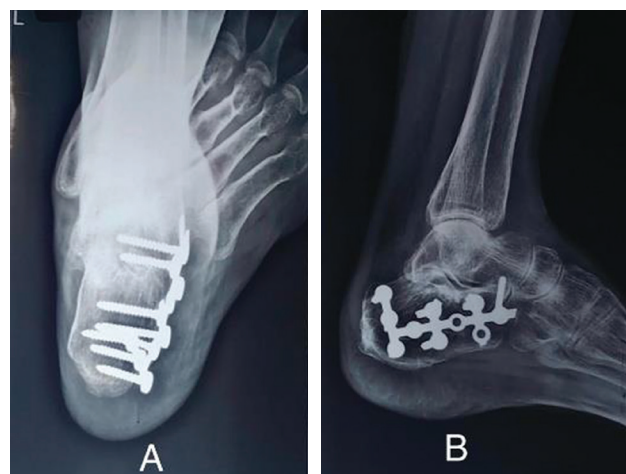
Immediate postoperative X-rays following calcaneal fracture fixation via lateral extensile approach (LEA). Antero-posterior view showing anatomical alignment and screw placement (A); lateral view demonstrating restoration of calcaneal height and contour with plate and screw fixation (B).
